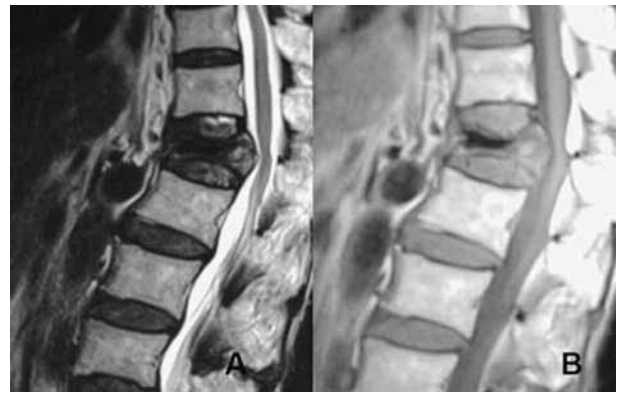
A : sagittal T2-weighted MR image showing a low signal intensity in the location of the cleft (classically, one would expect a high signal intensity) ; B : sagittal T1-weighted MR image also showing a low intensity.
